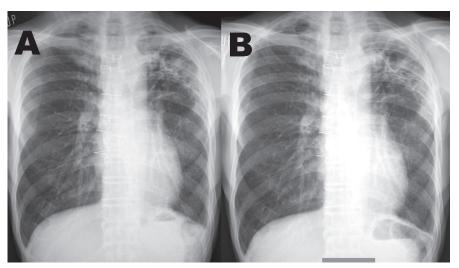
Chest radiographs obtained at discontinuation (A) and 1 month after discontinuation of oral itraconazol (B).
